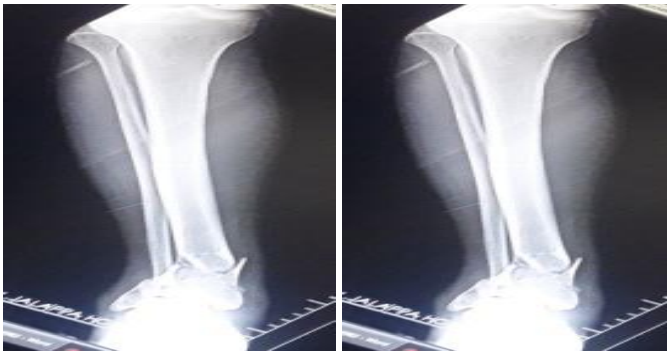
Preop X-ray AP view Lat view
